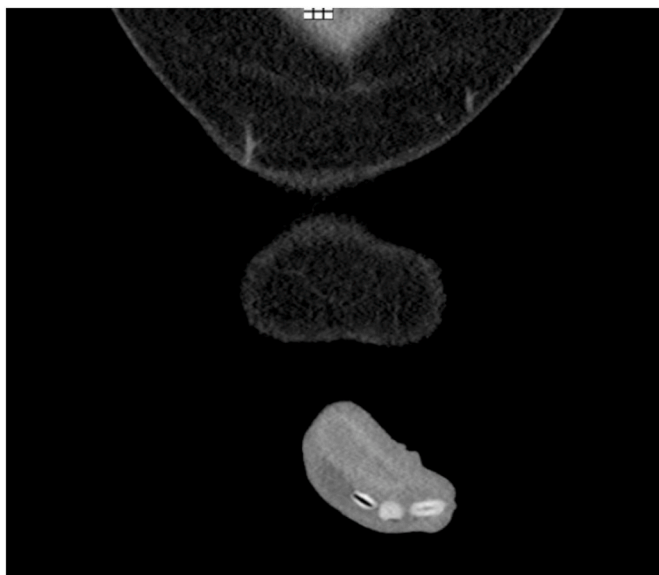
CT demonstrating three of the beans in the distal penile urethra.
